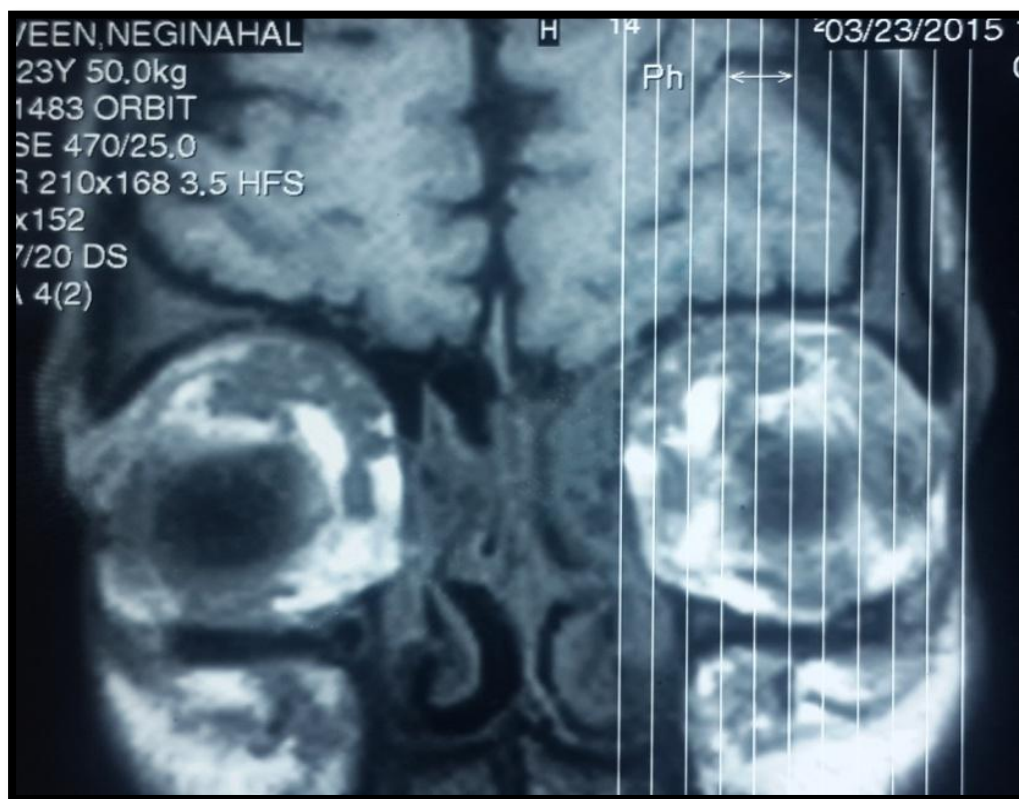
b MRI plain showing bilateral Orbital iso-intense lesions
